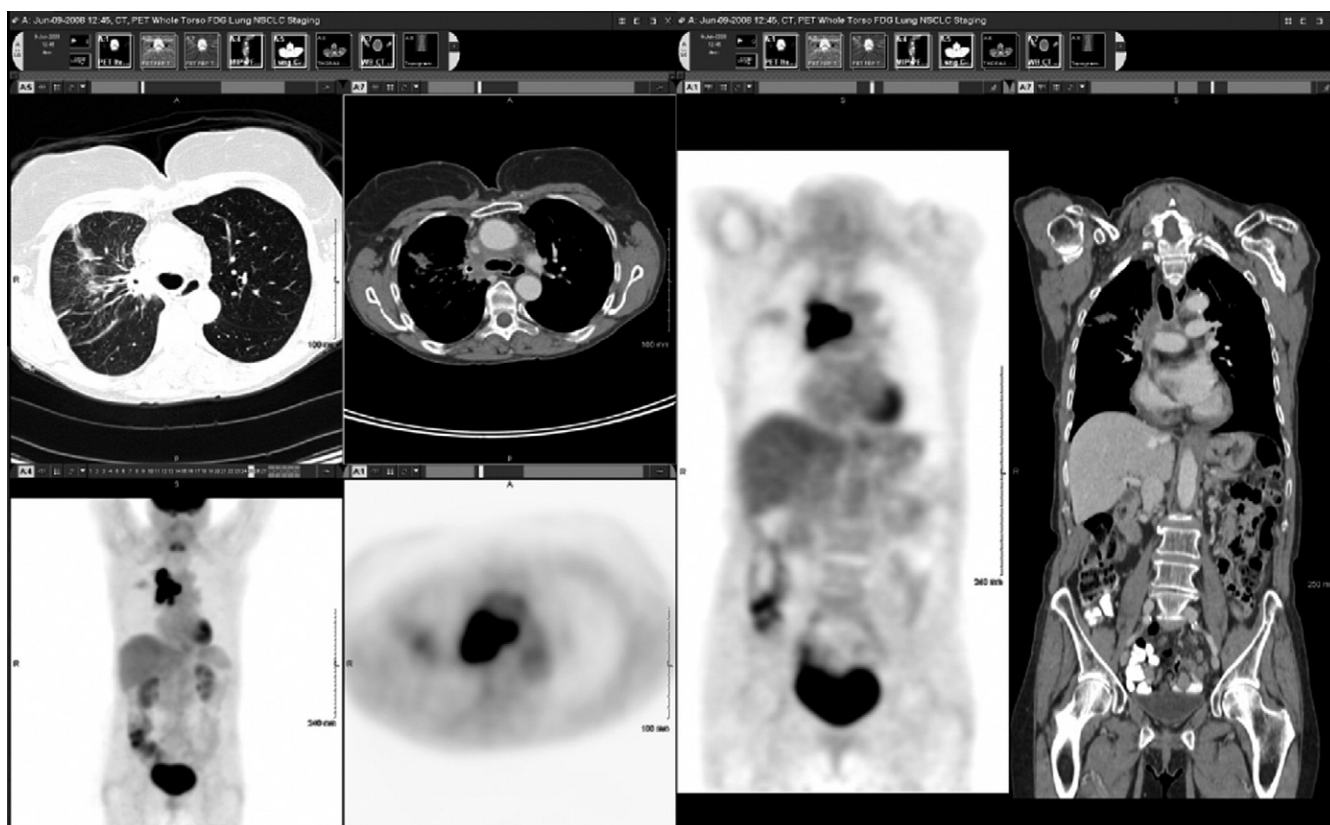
Typical display for interpretation of a body oncology PET-CT study. Images displayed include the maximum intensity projection (MIP) PET image (lower left hand corner of the left display screen), transaxial soft-tissue algorithm reconstructed CT images, and iteratively reconstructed FDG PET images (right side of left display screen), transaxial lung algorithm reconstructed CT images (lungs only, on the upper left hand corner of the left display screen), and the coronal reformat images of the iteratively reconstructed FDG PET images and soft-tissue algorithm reconstructed CT images on the right display screen. Note the size of the CT images, transaxial and coronal, are sufficiently large to allow for diagnostic interpretation. Other image reconstructions, including non-attenuation-corrected filtered back projection PET images and other CT reconstruction algorithms, can be introduced as needed from the thumb nail references at the top of the screen, and different level/window of the CT images displayed conveniently obtained by “hot keys” or drop-down menu. Increasing the number of images on the display decreases the image size to the point where interpretive utility is compromised.
